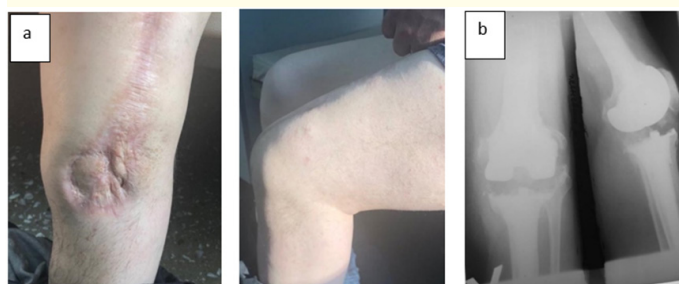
Pictures of the leg and X-ray clinical case 1/3 TLFU (48 months) after PL spacer implantation.
